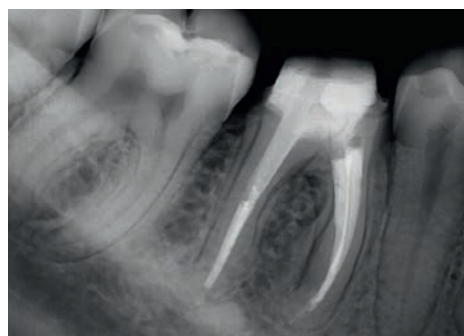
7-month post-op showing complete periapical healing.
